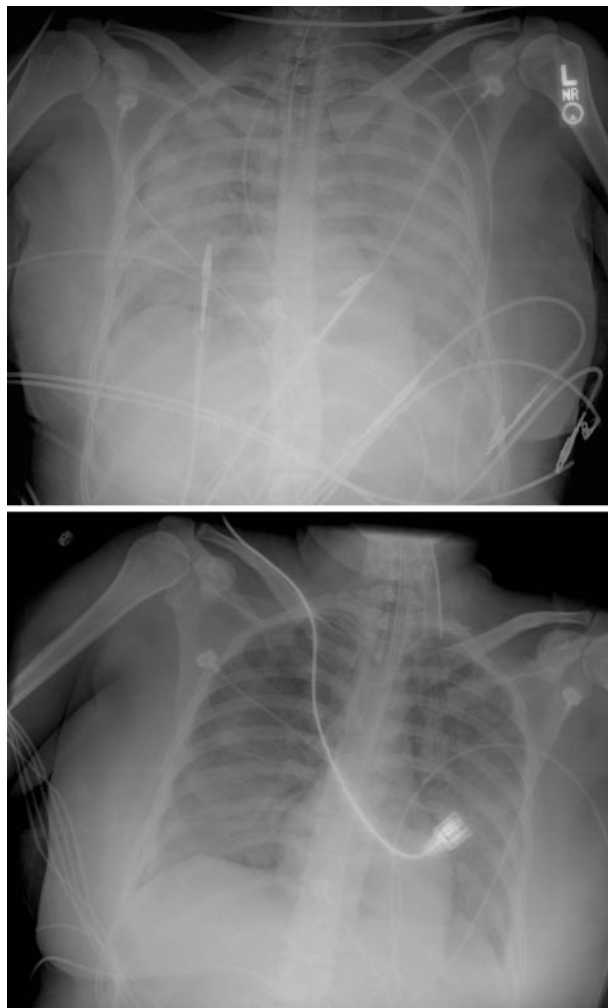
Top*: Anteroposterior chest radiograph from a 37-year-old woman with cholangitis who received 2 U of fresh-frozen plasma and acquired TRALI. The patient has an endotracheal tube in place and has diffuse bilateral alveolar infiltrates and a normal cardiac silhouette. This is a characteristic radiograph appearance for severe ALI in TRALI. *Bottom*: Anteroposterior chest radiograph from the same patient 24 h later showing significant resolution of the alveolar infiltrates, as seems to occur in 80% of patients with TRALI.
